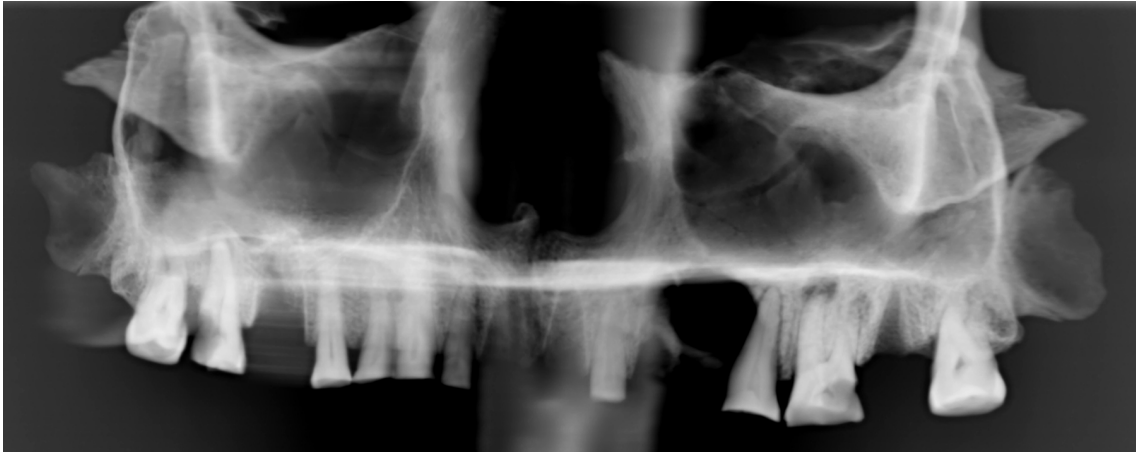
Panoramic radiograph image of the upper jaw: on both sides (M26, M17) periapical reactions are visible.
